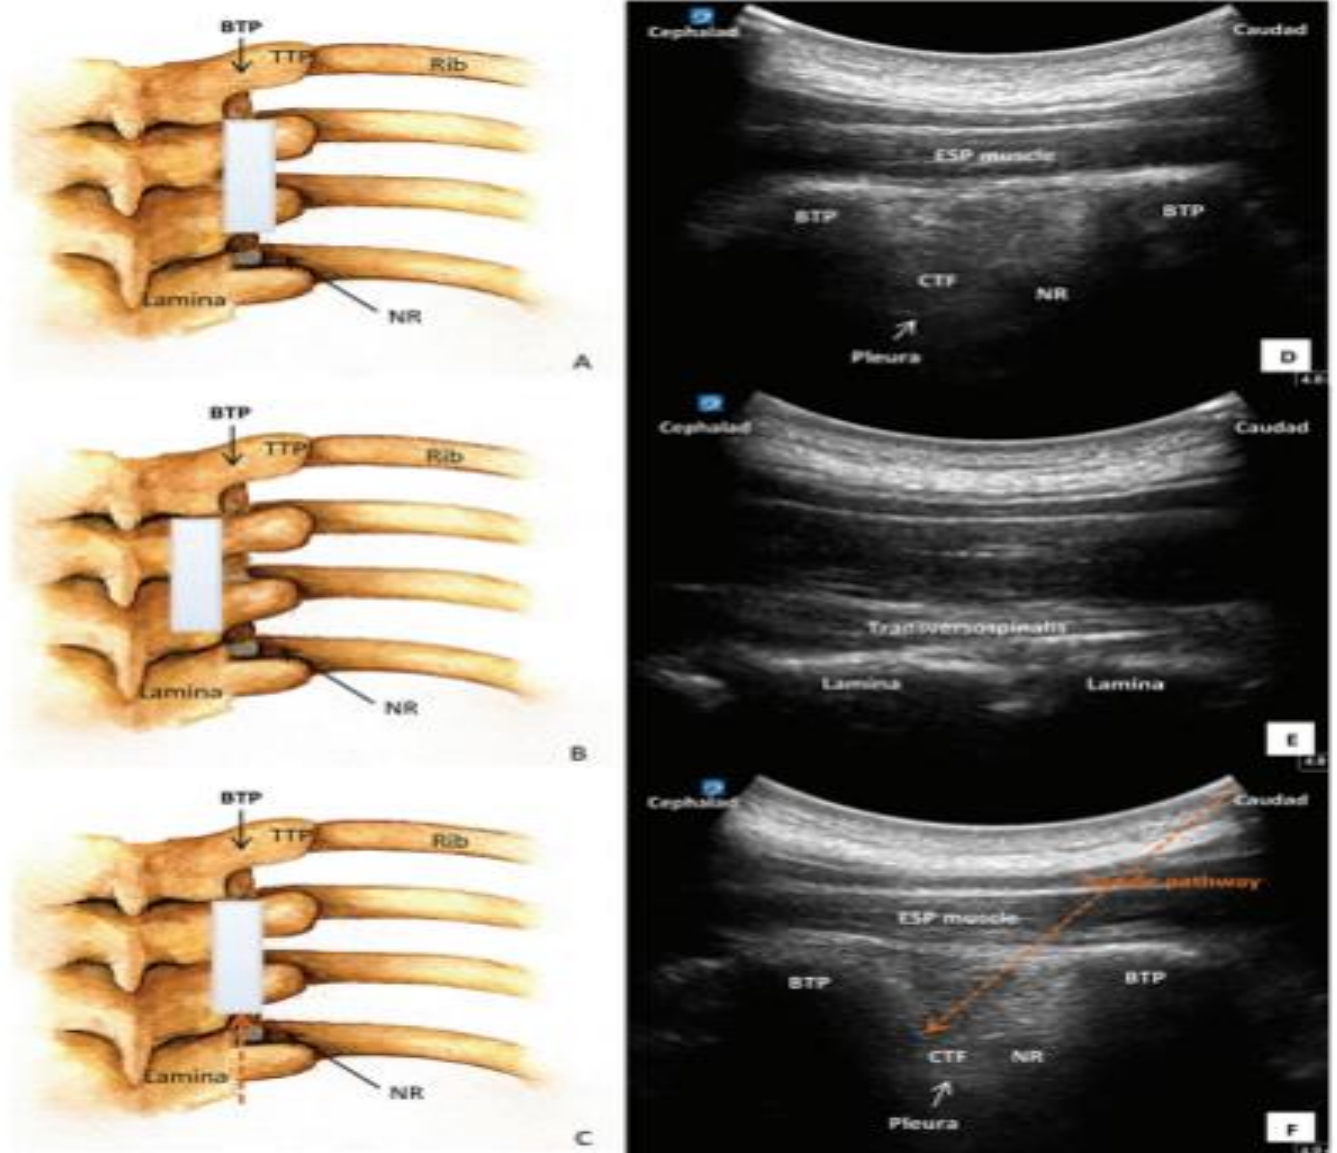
Posterior view of the thoracic spines and ribs from the ultrasound probe position (white bar, A–C) and ultrasonographic visualizations showing the base of the TPs and lamina in the sagittal plane for the CTF block (D–F). (A, D) The ultrasound transducer was placed between the bases of TPs (fourth to fifth). The bases of TPs appear more squared-off than the tip of the TP, which is deeper and close to the more obscure pleural line. The neck of fifth rib appears as a step-down of the hyperechoic convex line Antero superiorly to the fifth TP. (B, E) The ultrasound transducer was placed between laminae 4-5. (D, F) The ultrasound transducer was located at the level of the base of TP (fourth to fifth) using the in-plane needle approach where the needle was inserted from the caudal to cephalad direction into the anteroinferior part of the base of the fourth TP. BTP, base of TP; NR, neck of rib ⁽³⁴⁾.
